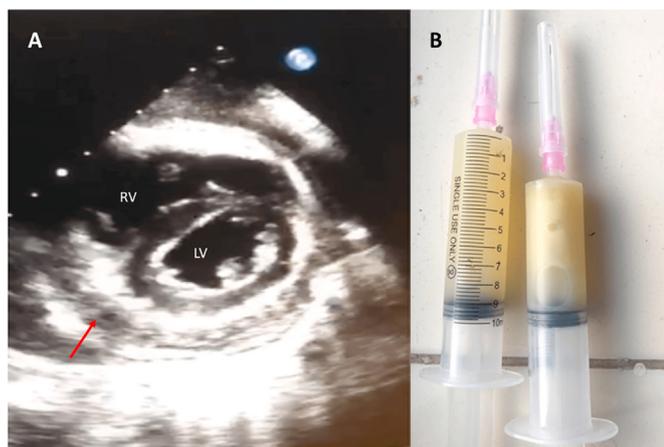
A. Echocardiographic parasternal short axis view showing large pericardial effusion (red arrow) and both ventricles, D shaped Left ventricle is also seen. B. The pus aspirated from the pericardial space. RV – right ventricle, LV – left ventricle
